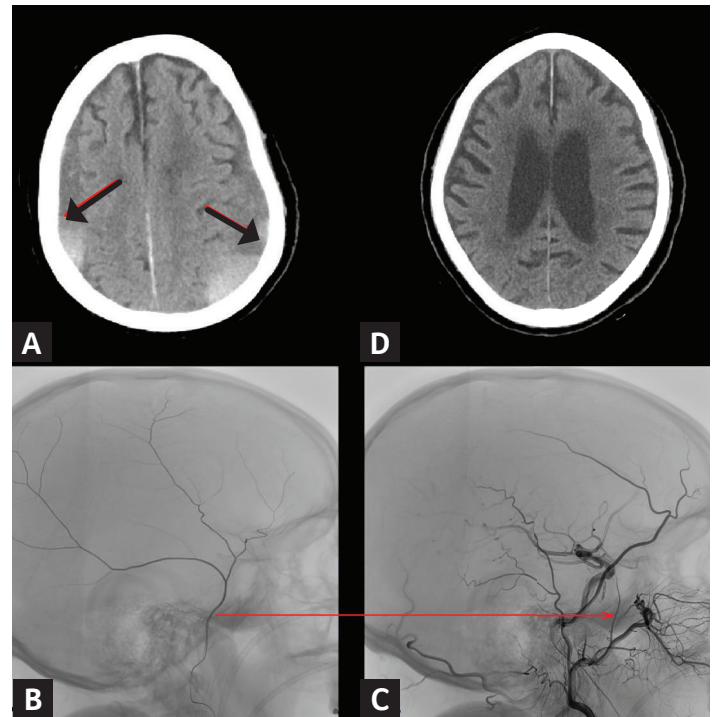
Preoperative axial CT (A) reveals a chronic subdural hematoma in an 89-year-old patient, who was treated with MMA embolization. Panel (B) demonstrates the patient's right MMA on lateral view. Panel (C) shows the same view after the embolization with particles and coils, where the MMA is completely missing (arrow). Panel (D) shows a follow-up axial CT after 2 months, where no residual hematoma can be observed.
